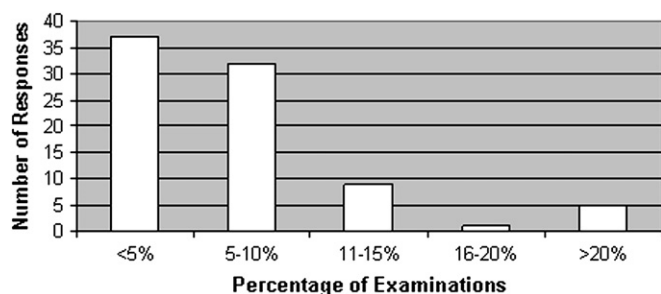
Percentage of outpatient MRI examinations that required anxiolytic medication at each of facilities included in survey.
